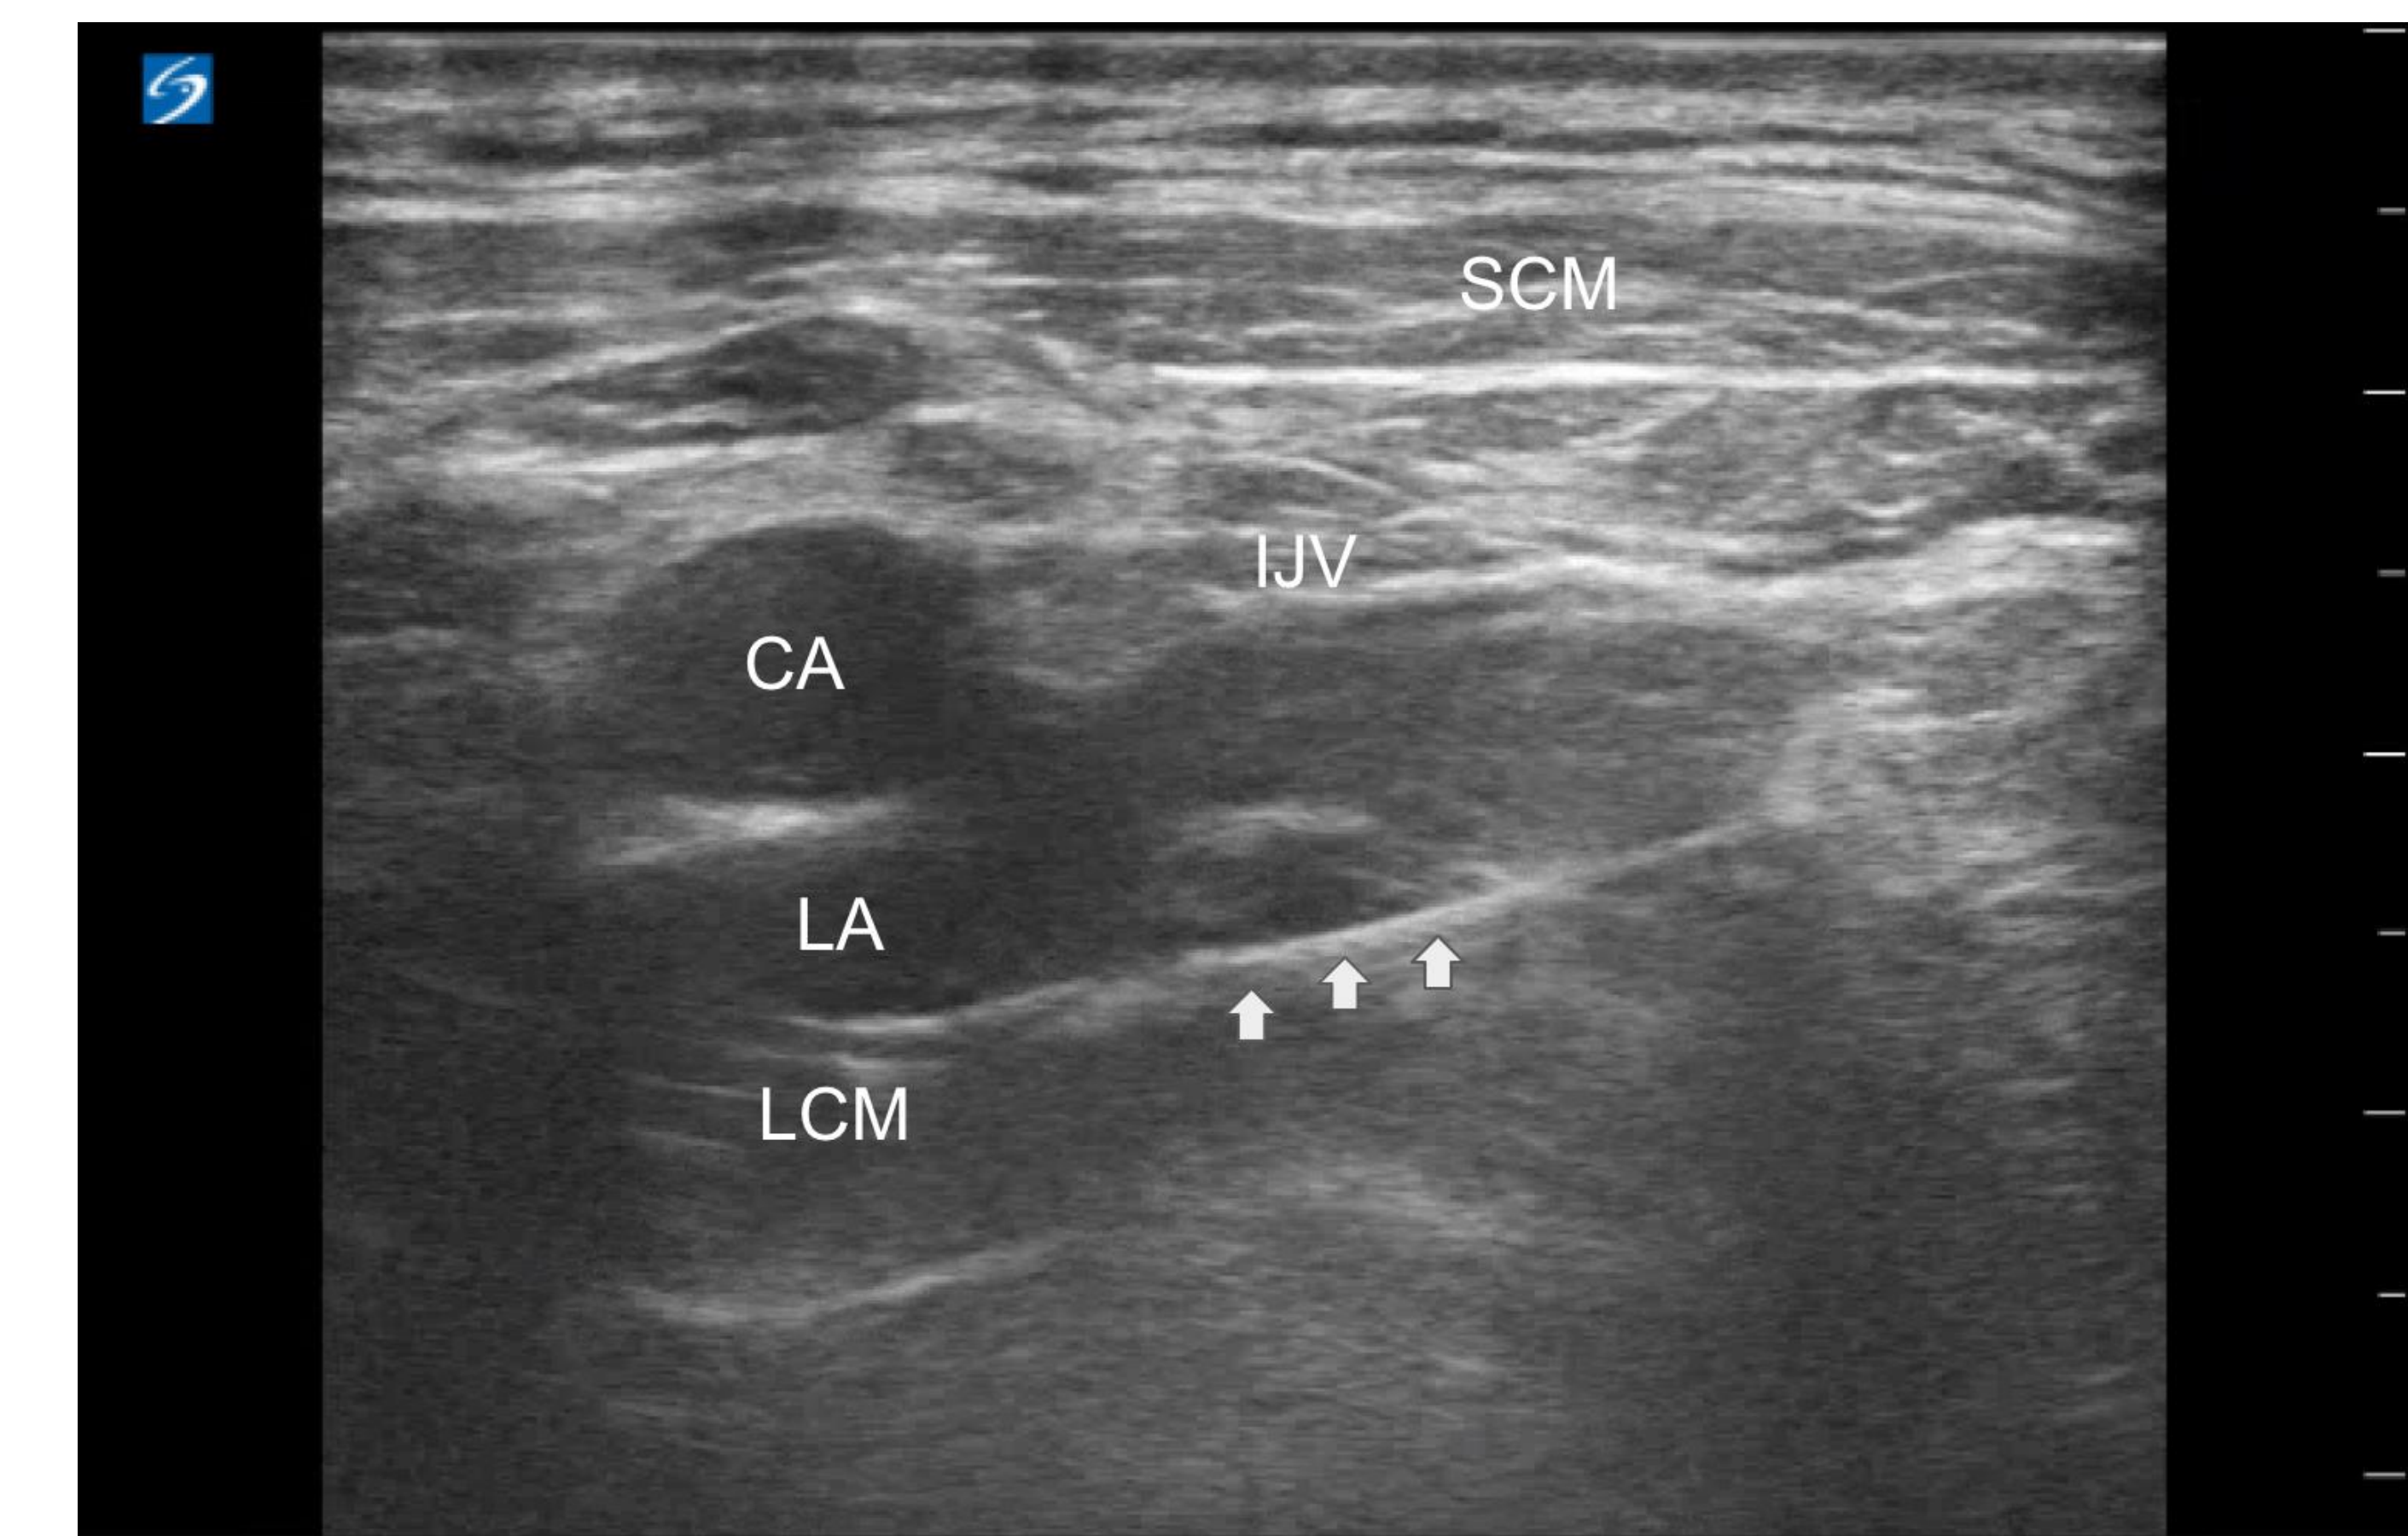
Ultrasound image from SGB. The longus colli muscle is depressed by the spread of local anesthetic.
